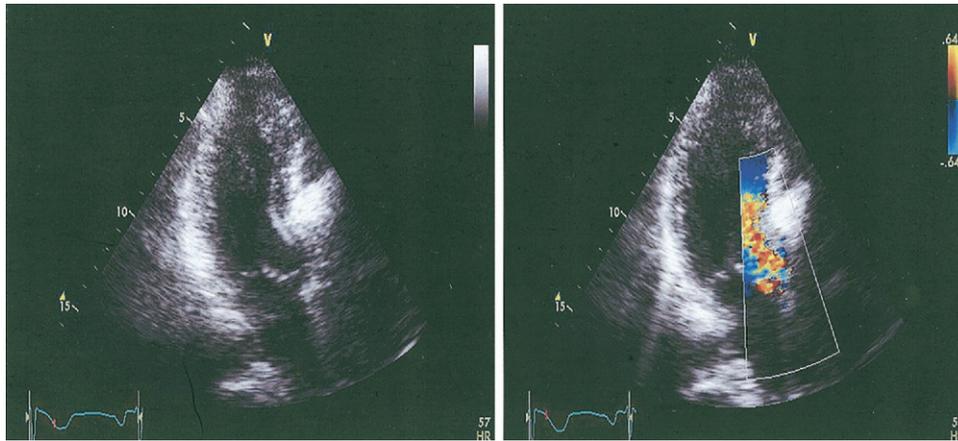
(Left) Apical long-axis view after opacification of septal base with radiographic contrast in the course of alcohol septal ablation. (Right) Color Doppler showing the site of flow acceleration in relation to the opacified septal base.
